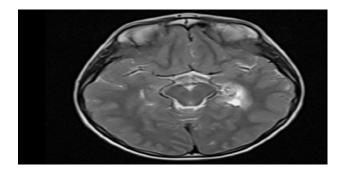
MRI brain-T2 w axial image showing volume loss with gliosis on left temporal regions.
